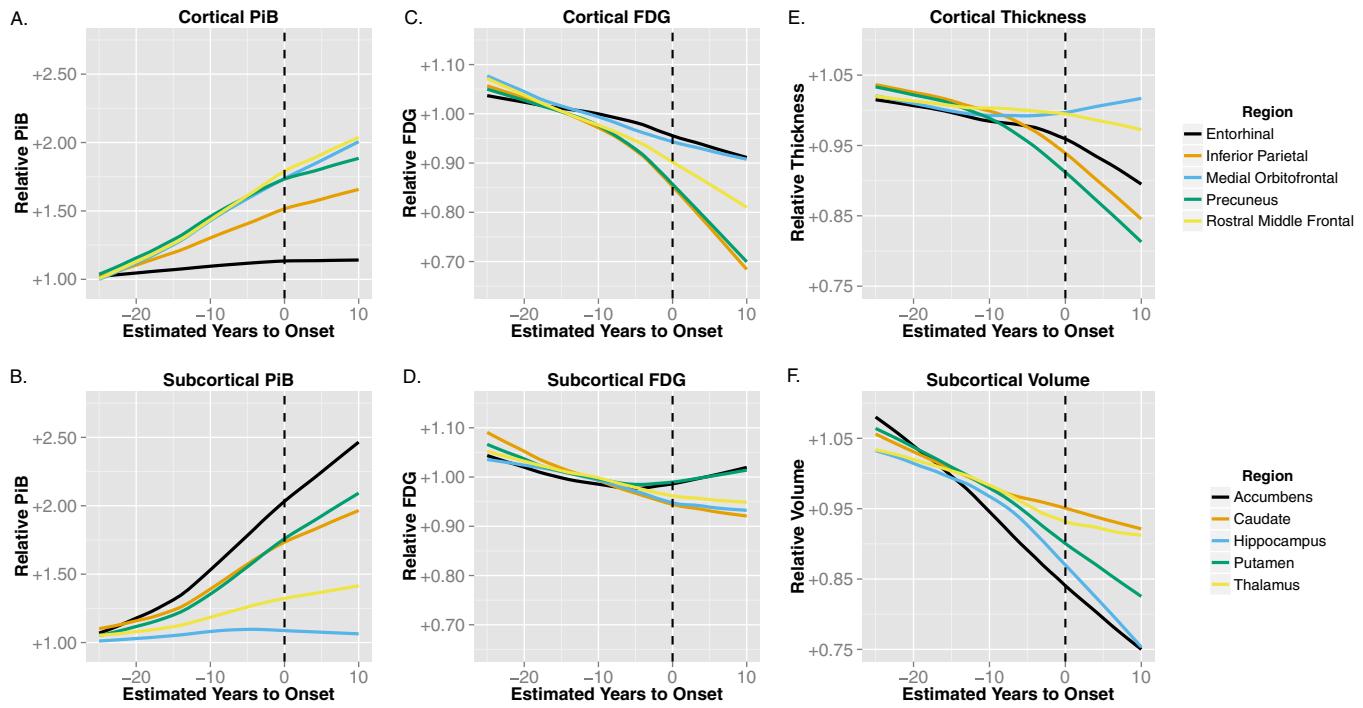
Biomarker trajectories without partial volume correction for PiB (A and B), FDG (C and D), cortical thickness (E), and subcortical volume (F). All conventions are the same as in Fig. 3.
